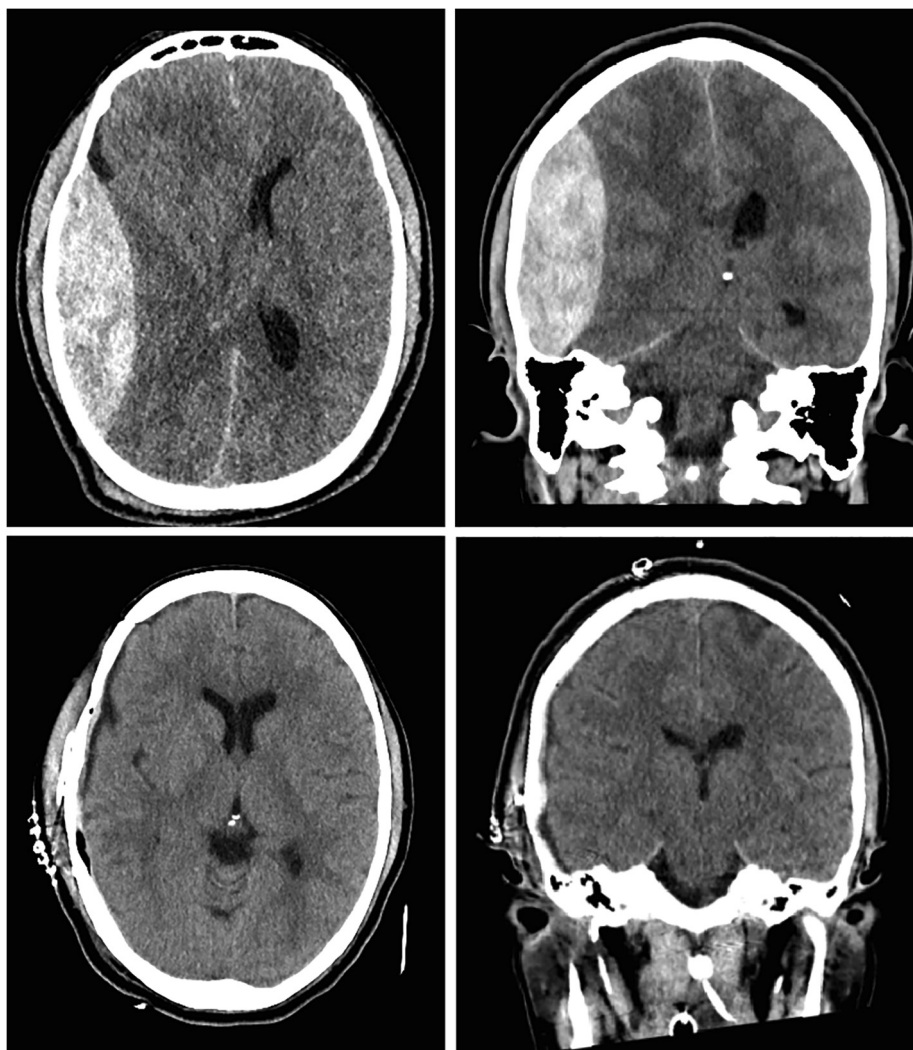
Preoperative (upper panels) and postoperative (lower panels) CT scan showing axial (left panels) and coronal (right panels) views of the parietotemporal extradural hematoma evacuated by craniotomy.
